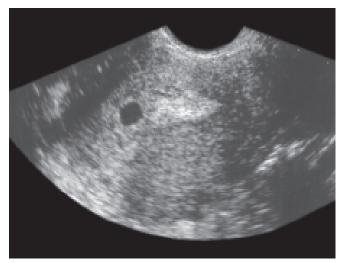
Transvaginal ultrasound image demonstrating an early gestational sac prior to the visualization of a fetal pole
